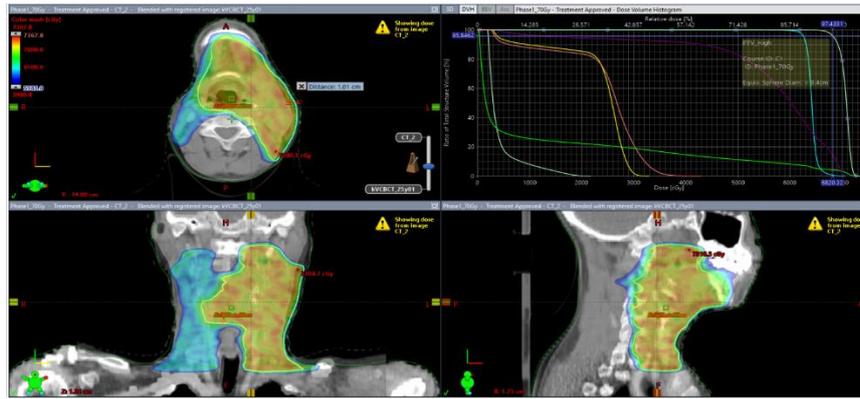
Dose distribution on the 25th fraction iCBCT blended with reference planning images
